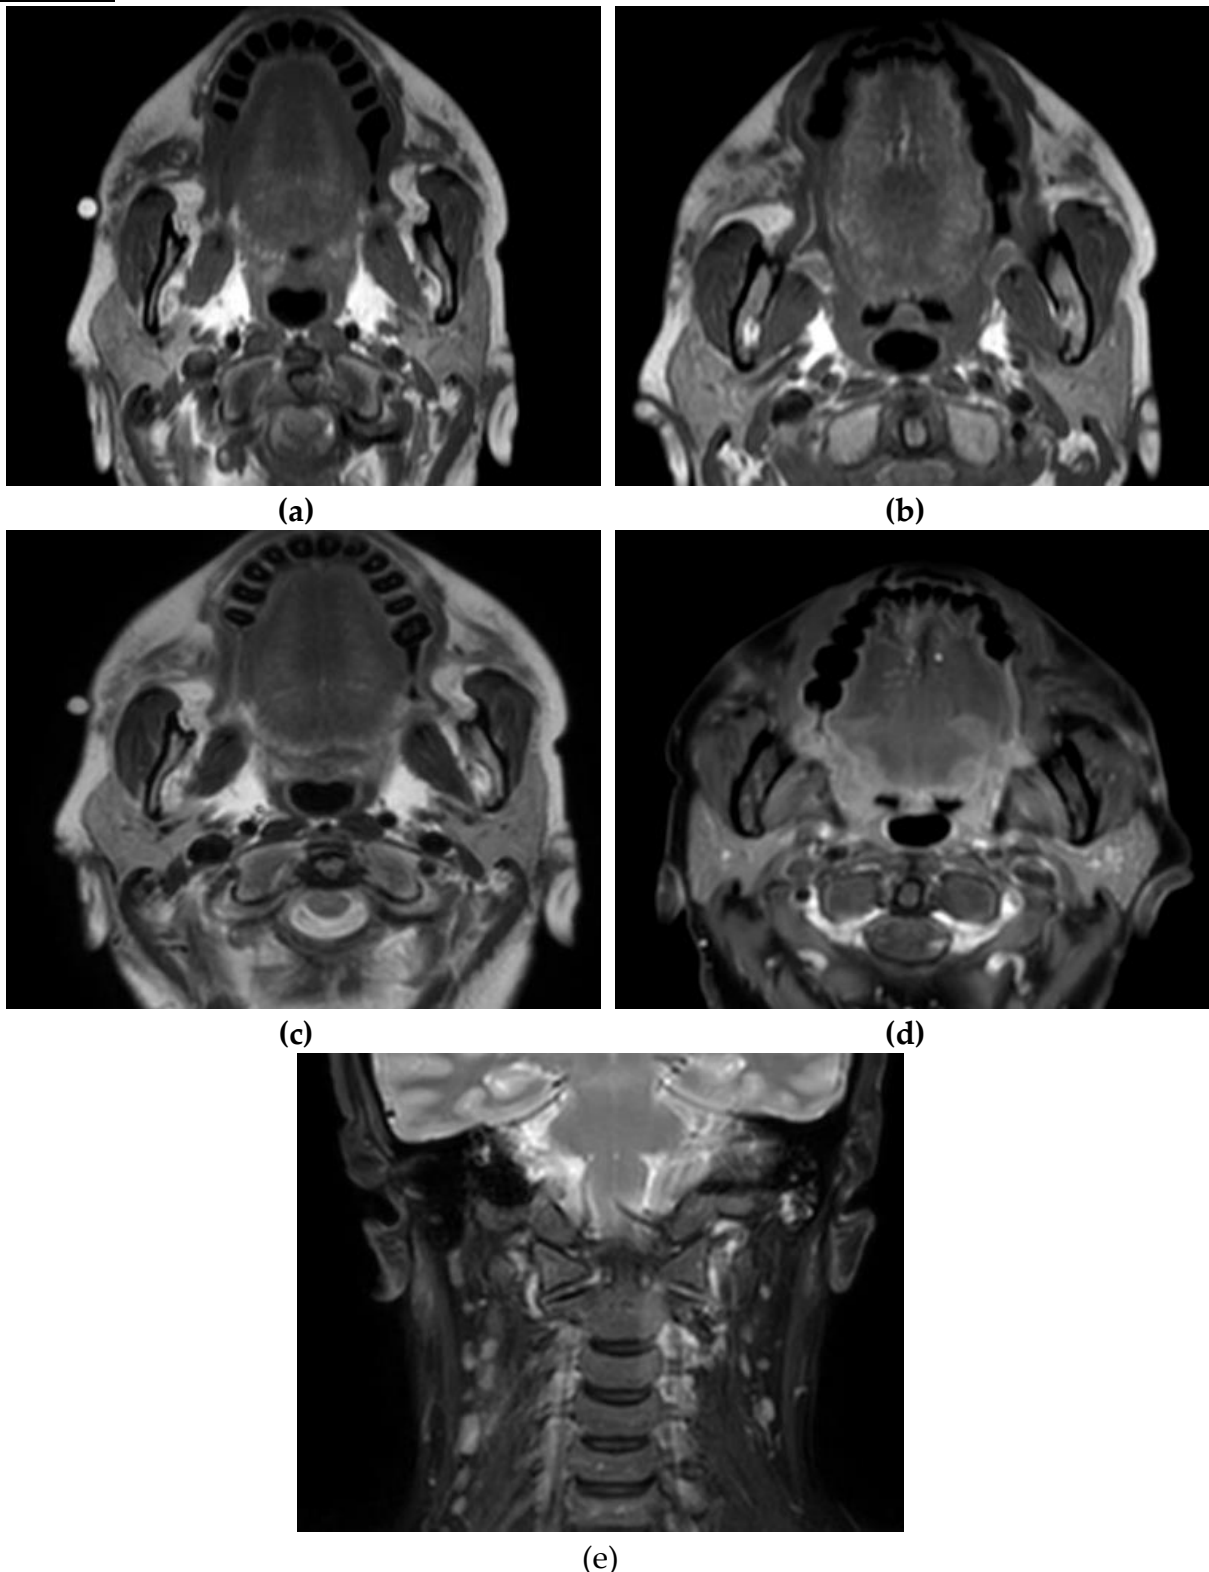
Case with FNG; 33 -year-old lady complained of painful swelling, MRI- showing the signal pattern of the FBG; fibro-nodular granuloma (a, b) axial cuts T1W sequences, reveals intermediate signal of nodular fibrotic streaks, (c) axial cuts of T2W sequence showing the nodules as intermediate signal, (d) axial cuts T1 FATSAT post contrast shows mild enhancement of the nodules.
